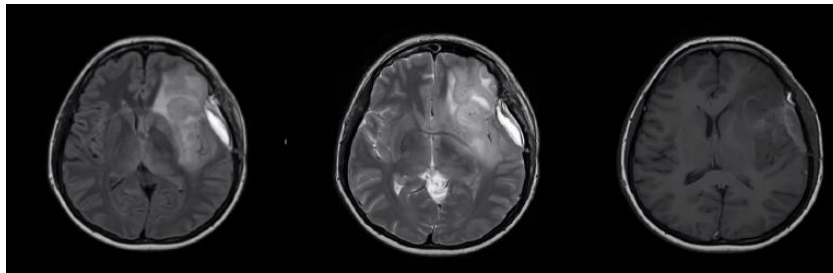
Non-Contrast Head MRI of Patient Post-Biopsy on T1, T2, and T2-Flair sequences.
